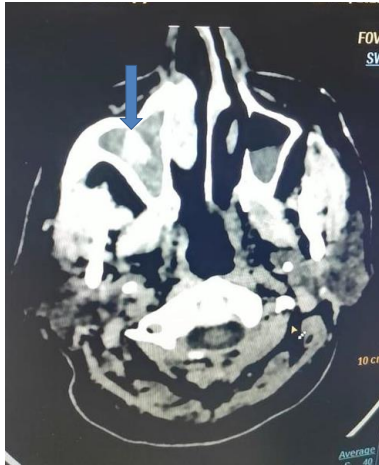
CT PNS showing right maxillary sinusitis with hyperdensity.
